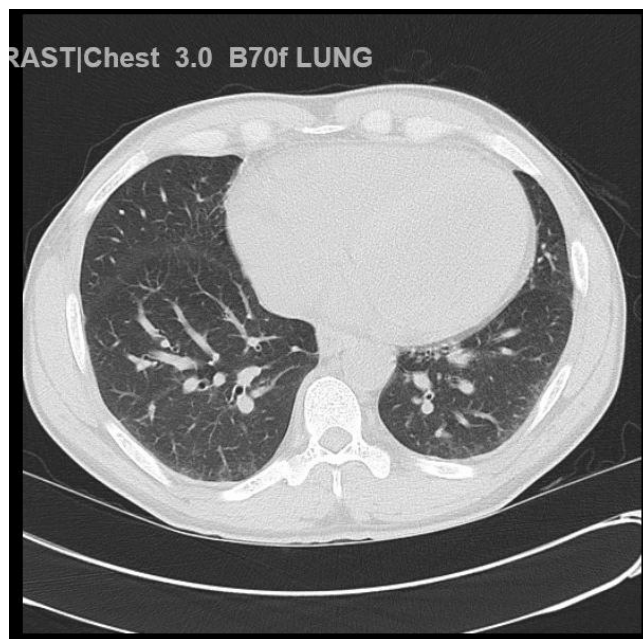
CT Chest was insignificant
